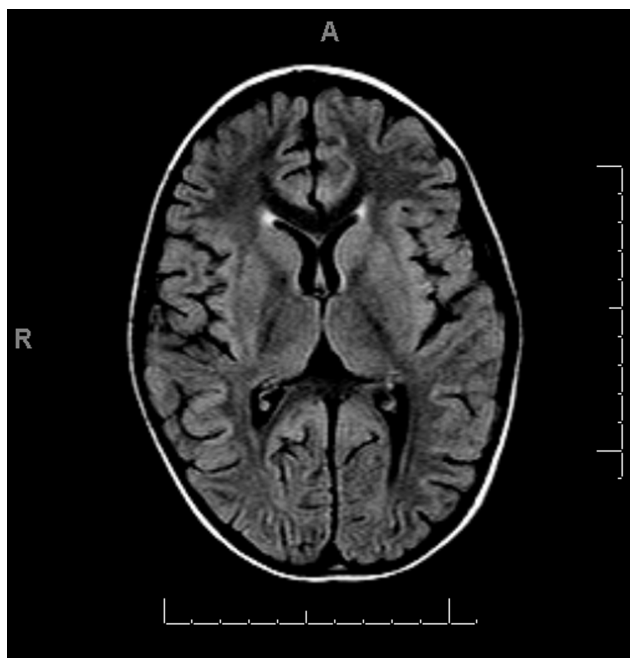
Control MRI shows no abnormal signal of basal ganglia on FLAIR image.
